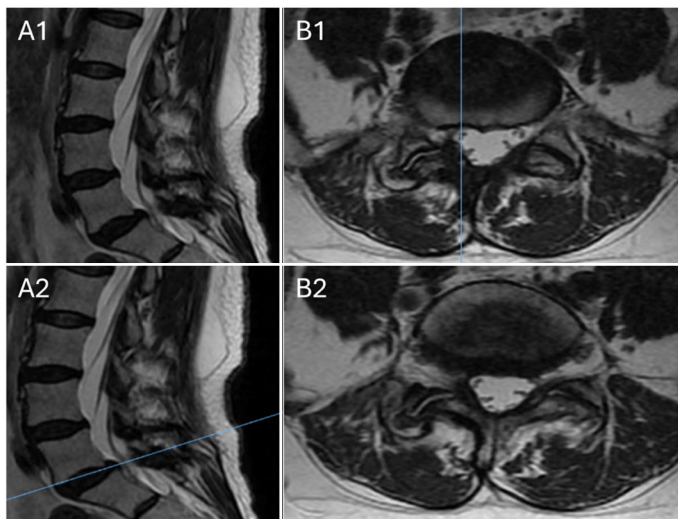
Postoperative magnetic resonance imaging, sagittal cuts (A) and axial cuts (B), showing decompression of nerve root.
